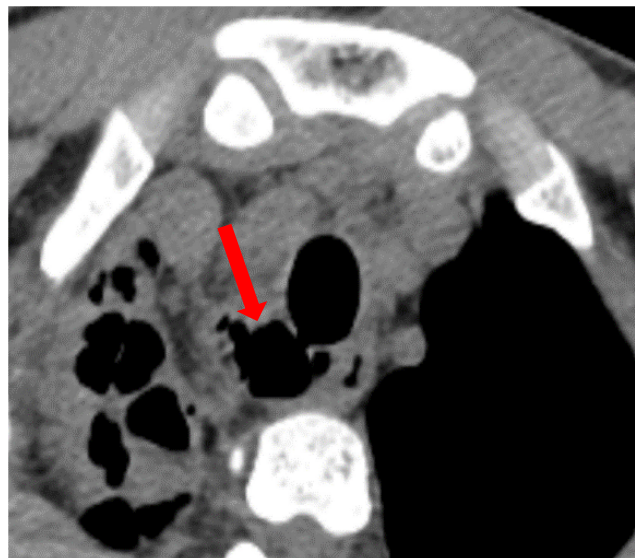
CT thorax shows the tracheal diverticula. (red arrows)
